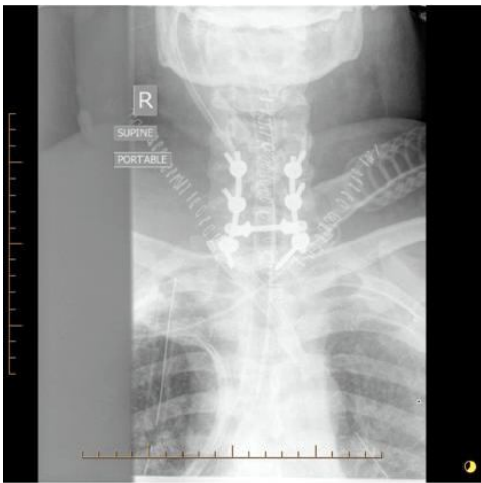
X-Ray post pectorals flap for esophageal repair
